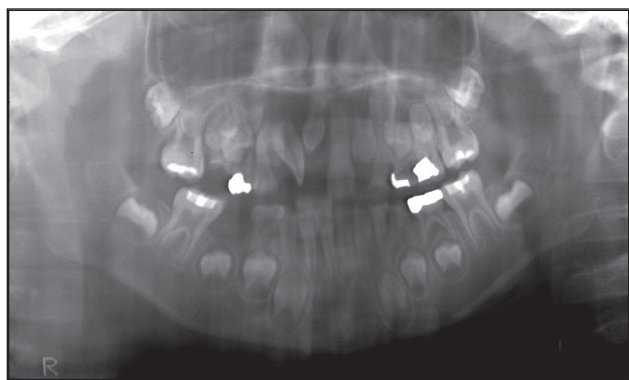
Panoramic radiograph of an 8-year-old patient showing rotation of the upper right central incisor and impacted supernumerary tooth.
